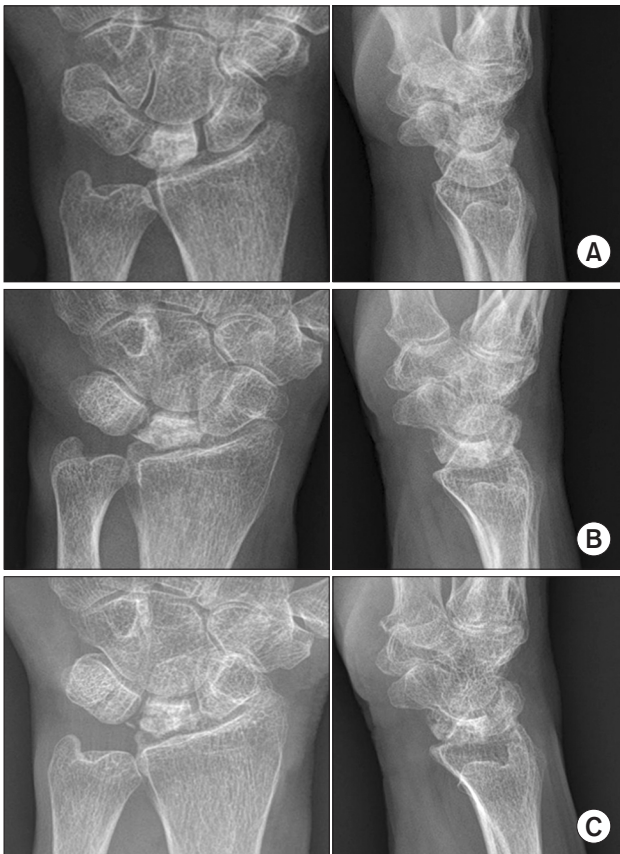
Wrist pain persisted for 5 years in a 66-year-old woman. (A) Plain radiographs showed Kienböck's disease (Lichtman stage 3A) and chronic synovitis at the dorsum of the wrist. For the latter condition, passive stretching exercise and pain control using nonsteroidal anti-inflammatory drugs were recommended. (B) One year later, apparent collapse of the lunate with persistent radiographic sign of the synovitis could be found. (C) After continuous observation of additional 4.7 years, the lunate did not collapse further, with radiographic signs of the synovitis no longer apparent. Intermittent pain of twice a month was the only remaining symptom.
